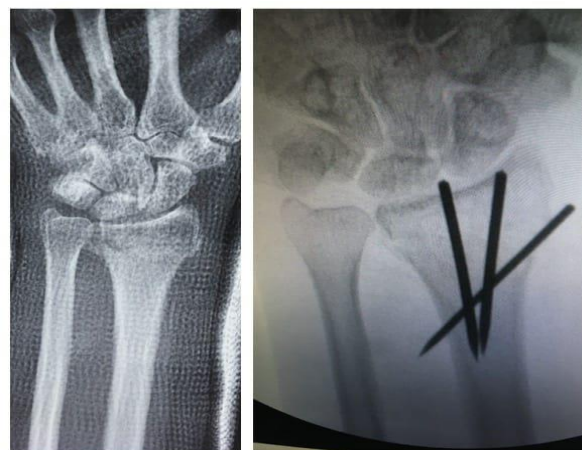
Preop & Postop X-ray Ap View
